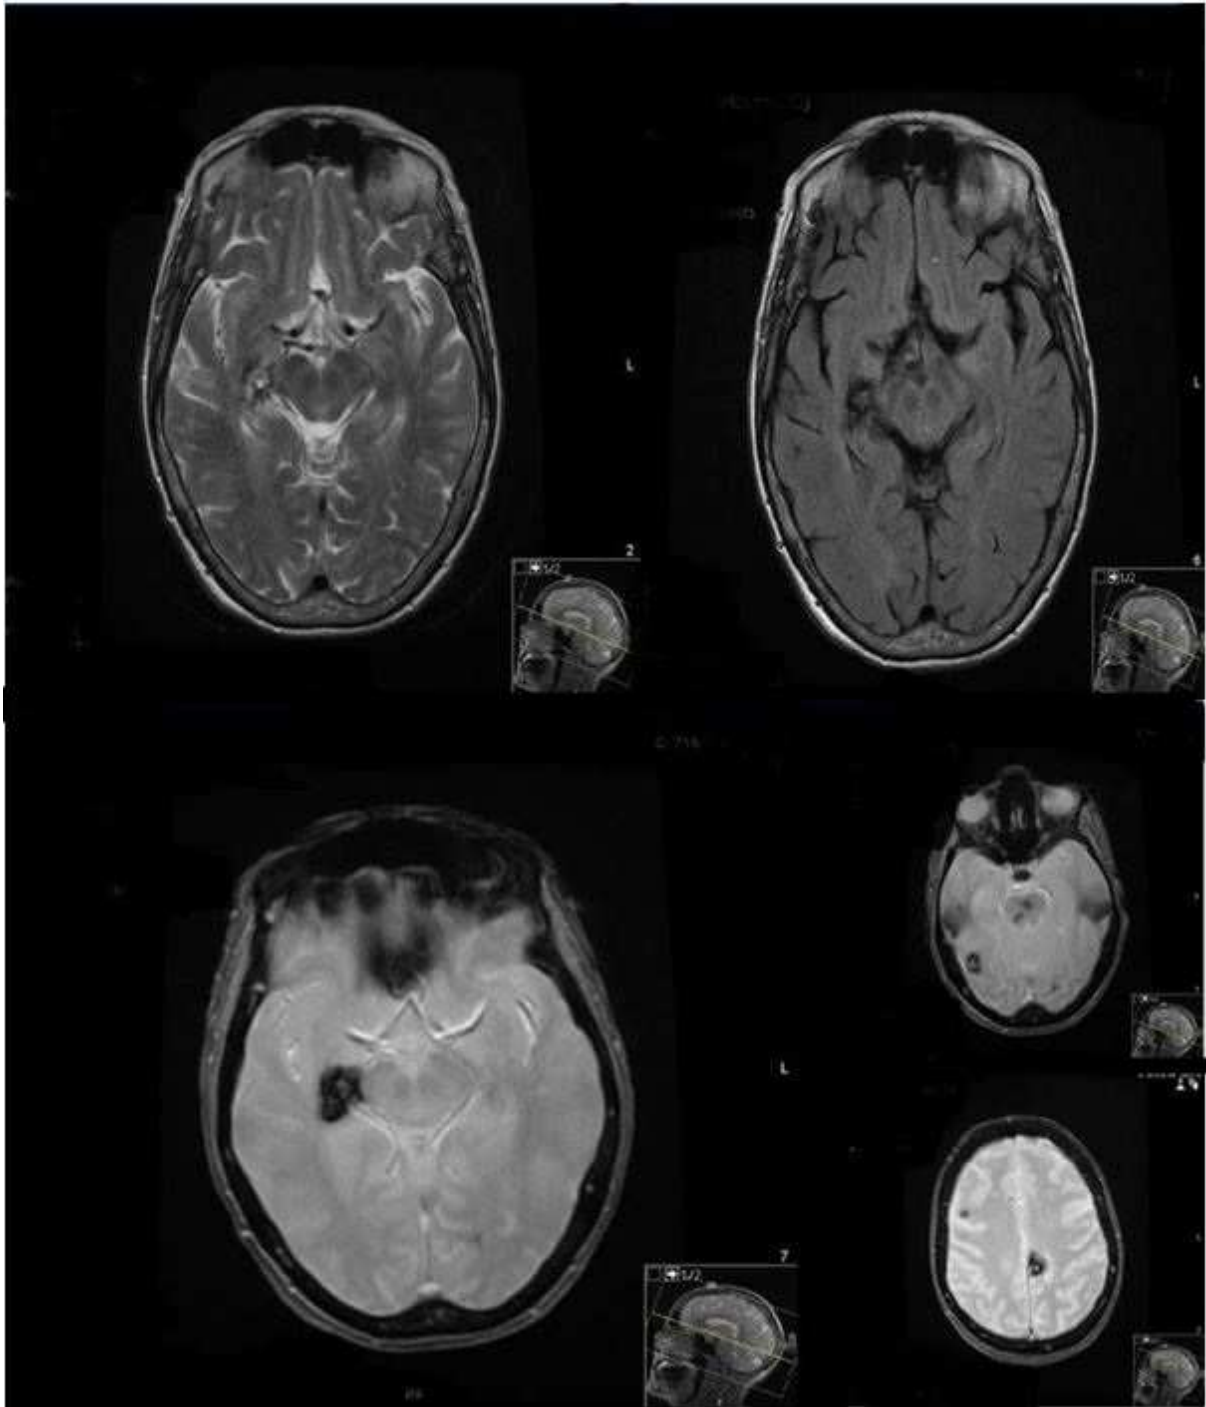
Initial MRI in January 2013 showing multiple intracranial lesions with T1 shortening consistent with multiple cavernomas with evidence of previous hemorrhage
